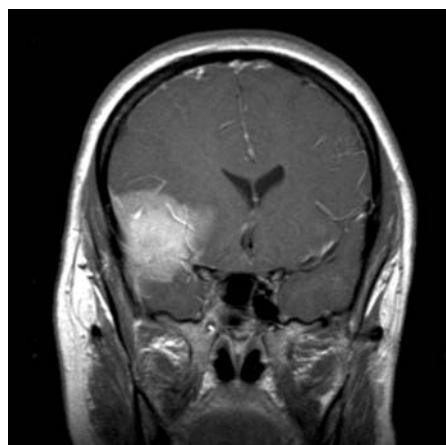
T1-weighted MRI with gadolinium showing large, irregular meningeal mass displaying an indistinct interface with adjacent brain and marked mass effect.
